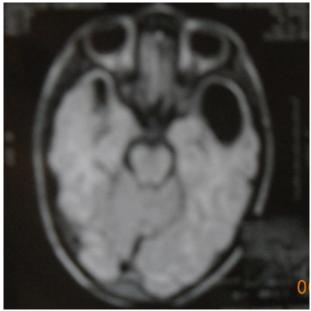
T1-weighted axial image showing subcortical cysts in the temporal lobes
